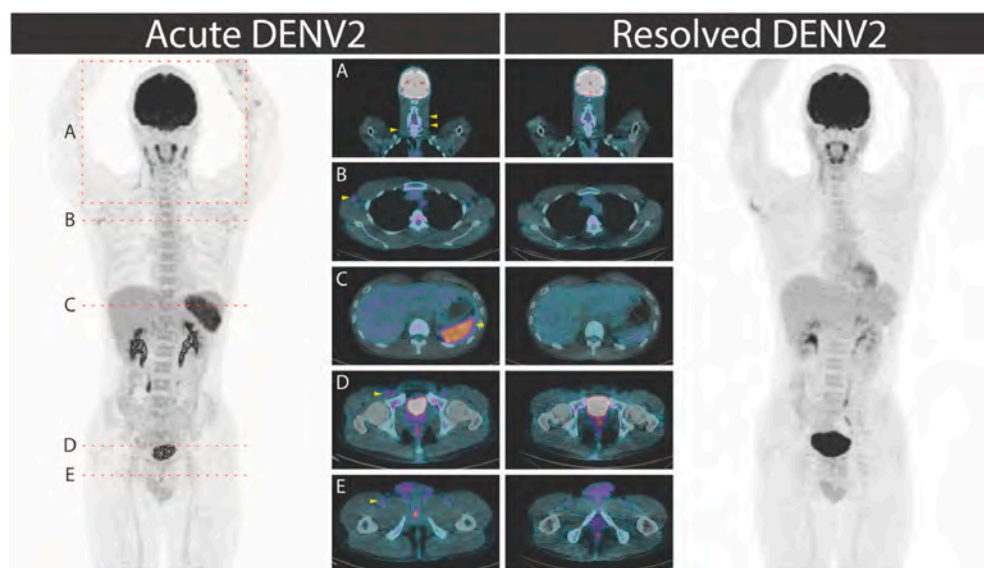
^{18}F -FDG PET/CT images of Patient B at the time of acute (Day 5 illness) and resolved (convalescent) DENV2 infection. The yellow arrows indicate sites of increased ^{18}F -FDG uptake in the cervical (A; maximum standardized uptake volume of ^{18}F -FDG [SUV_{max}]: 6.0), axillary (B; SUV_{max} : 3.5), external iliac (D; SUV_{max} : 3.3), inguinal and femoral lymph nodes (E; SUV_{max} : 2.5), and spleen (C; SUV_{max} : 8.5) during acute infection. Imaging at convalescence shows metabolic resolution of ^{18}F -FDG uptake at these sites. ^{18}F -FDG uptake seen in the brain, liver and urinary system is physiological and within normal expected limits.
